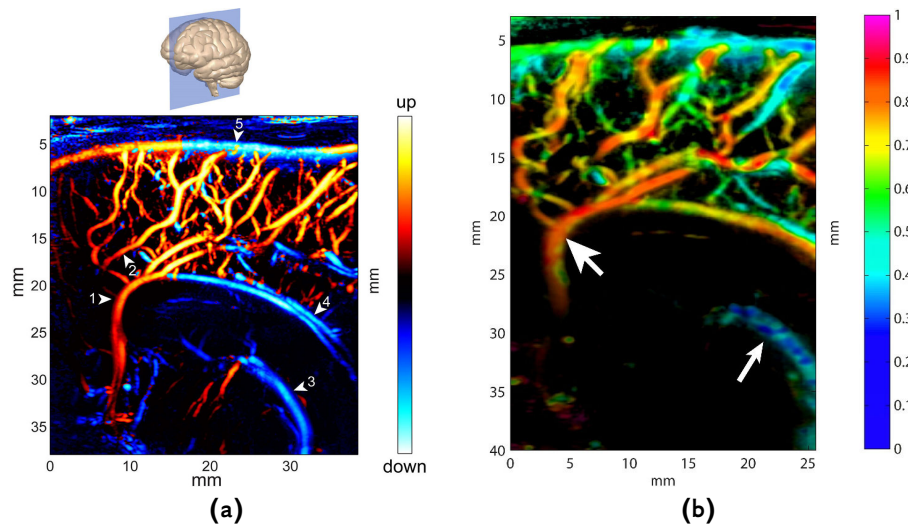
Ultrafast ultrasound studies of the brain. (a): A directional ultrafast Power Doppler sonogram showing the direction of the blood flow in the neonate brain and the plane in which the sonogram has been taken. (b): A map of resistivity of brain vessels (the definition of resistivity is based on cyclic variations of the velocity of the blood flow), which allows one to distinguish arteries from veins. It is demonstrated that arteries normally have a resistivity index between 0.75 and 0.9 (red and orange, the large-head arrow), while the resistivity index of veins is below 0.45 (blue, the small-head arrow). Note that clear discrimination between the arteries and veins is achieved even when they lie close to or overlay each other. Reproduced from [Demené et al. \(2014\)](#)
